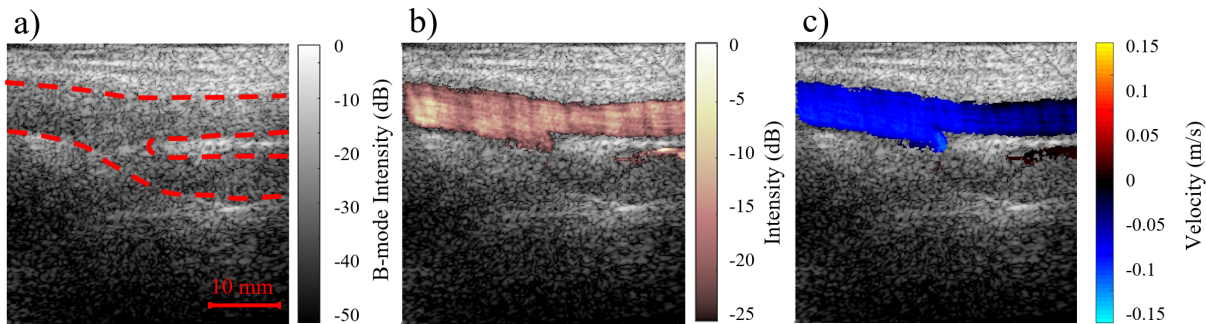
The femoral bifurcation. *a)* B-mode image. Red dashed lines indicate the arterial walls. *b)* Power Doppler image. *c)* Colour Doppler. Flow pixels are assigned a colour depending on whether they represent flow towards (red) or away from the transducer (blue). Only pixels with flow magnitudes over a defined threshold are assigned colours. At this moment in the cardiac cycle flow is only visible in the upper branch of the bifurcation.
